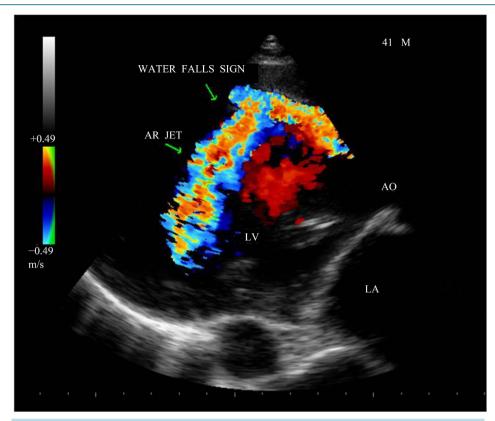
Parasternal long axis view showing the AR jet falling into the LV with a typical appearance of a "water fall".
